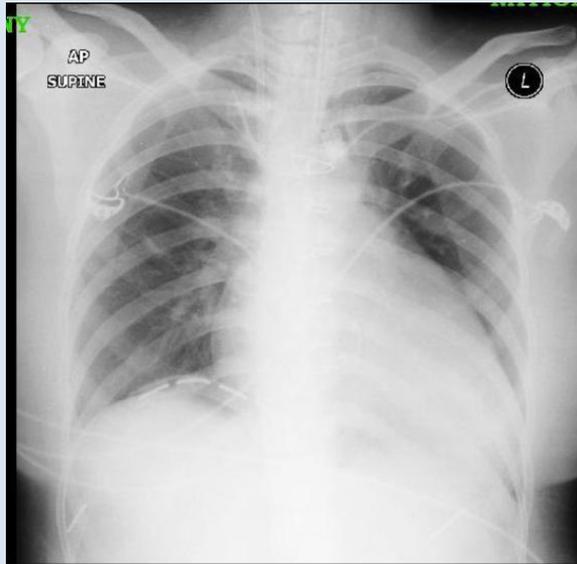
Chest X-Ray post Cone Reconstruction
